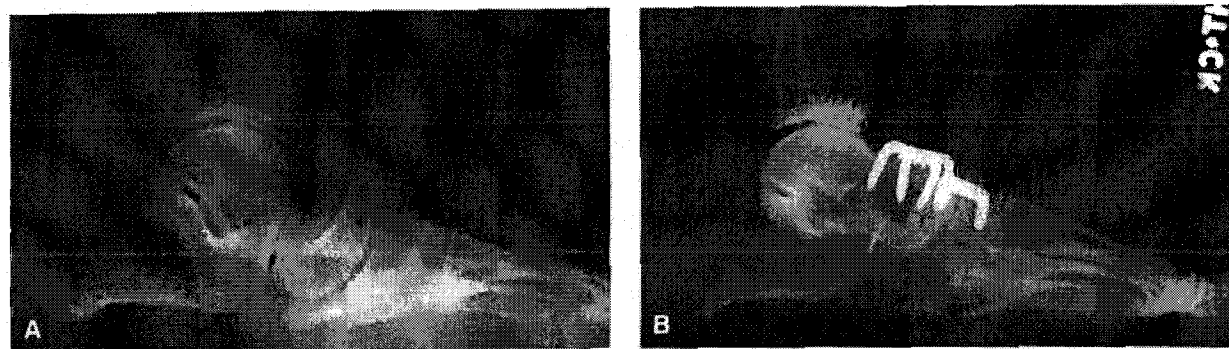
Preoperative (A) and postoperative (B) lateral radiographs demonstrating significant medial column faulting corrected by double medial column fusion.
